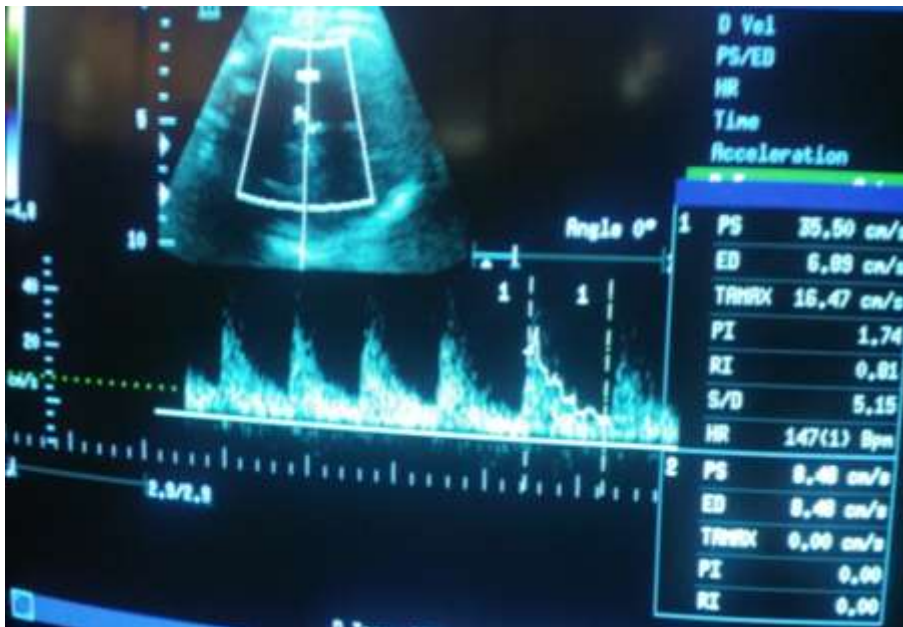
b) shows color Doppler middle cerebral artery waveform at 38 WKs
